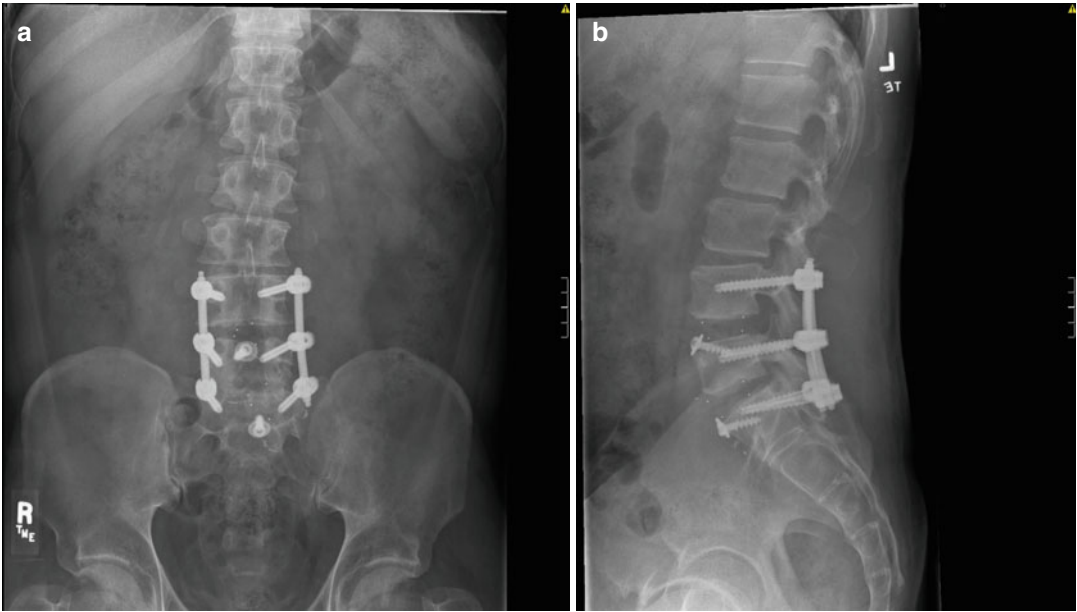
Posteroanterior (a) and lateral (b) radiographs demonstrating L4–5, L5–S1 anterior lumbar interbody fusion with femoral ring allograft and supplemental posterior transpedicular fixation
